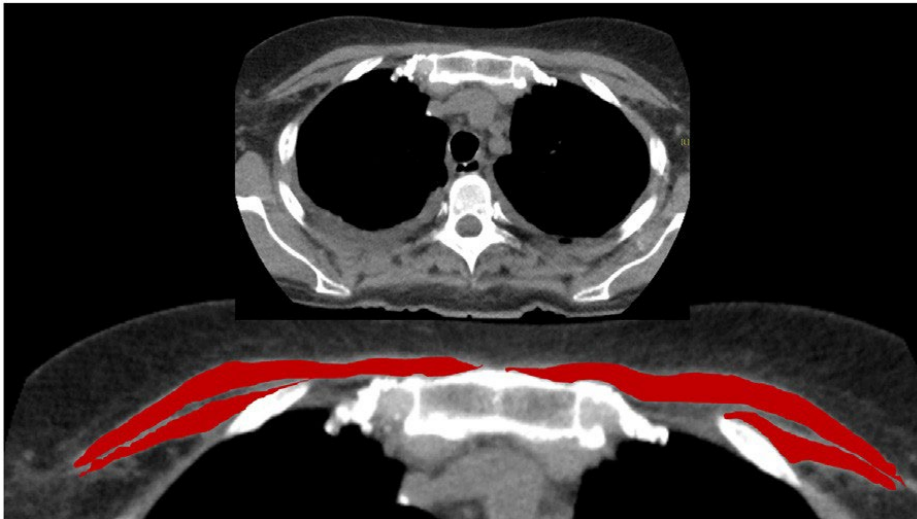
Thorax-CT einer 55-jährigen Patientin mit COVID-19. Die identifizierten Muskelparameter waren: PMA 14,48 cm<sup>2</sup>, Muskeldichte 28 HU, PMI 5,19, SMG 145,3. Die Patientin starb am Tag 19 nach Aufnahme.
